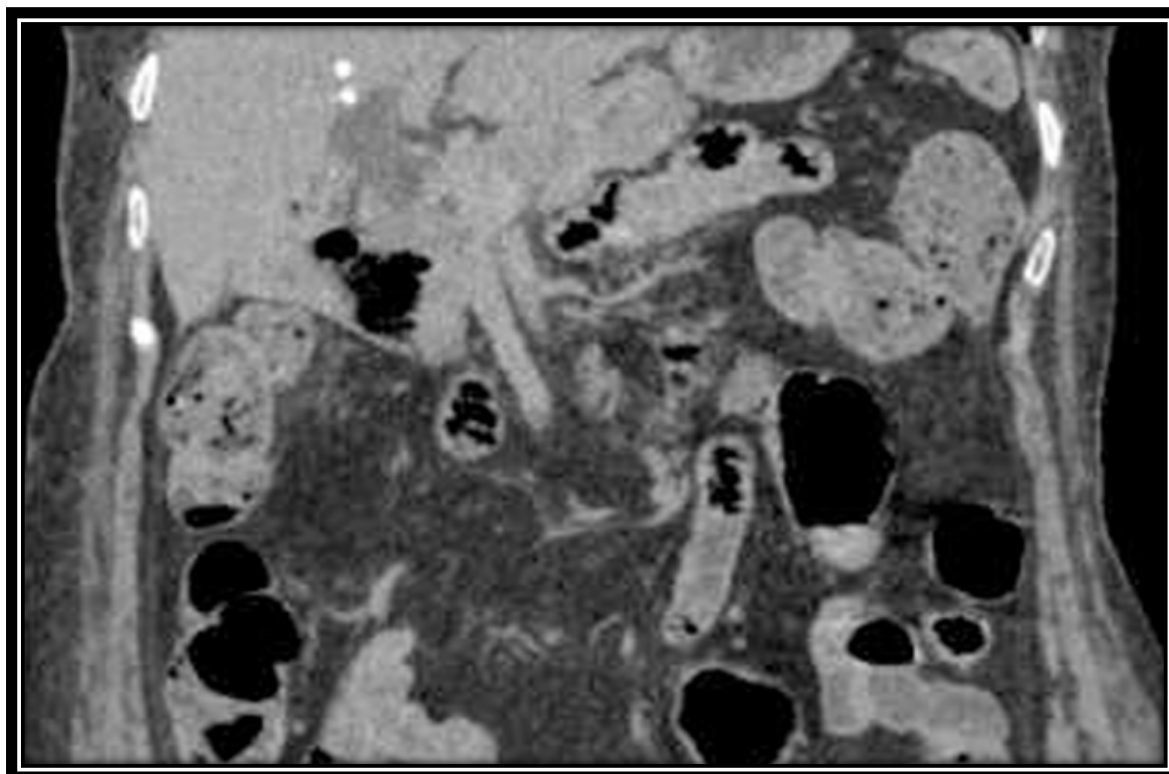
Coronal Contrast-Enhanced CT Image Demonstrating Incidentally Detected Periapillary Duodenal Diverticulum
